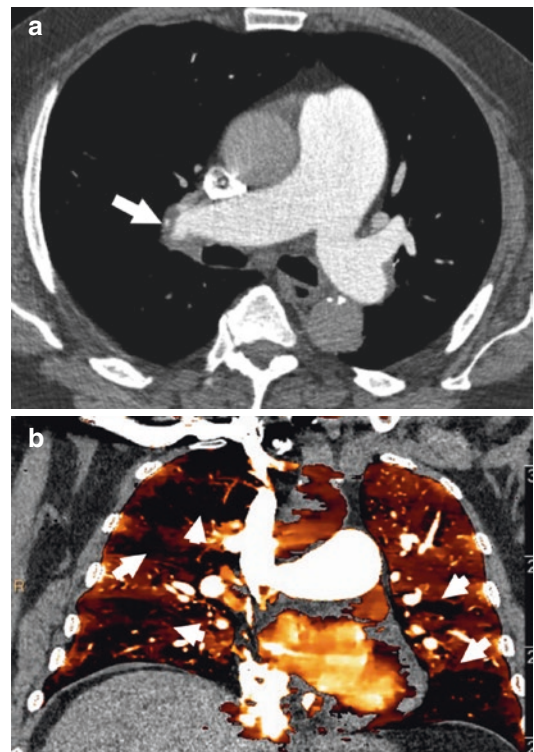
Chronic pulmonary embolism. (a) Axial CTA image shows an eccentric filling defect with calcification in the right pulmonary artery (arrow), consistent with a chronic pulmonary embolus. The central pulmonary arteries are dilated due to pulmonary hypertension. (b) Coronal dual-energy lung perfusion map in the same patient shows multiple filling defects in bilateral lungs (arrows), caused by the chronic thromboembolism
